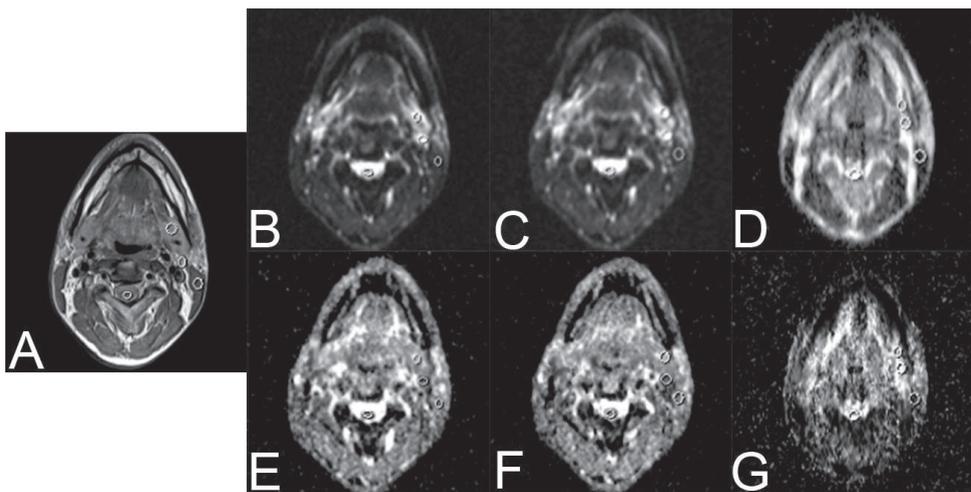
Example of regions of interest (ROIs) drawn on T2 (A), EPI-DWI-2b b_0 (B), EPI-DWI-6b b_0 (C), TSE-DWI-2b b_0 (D), EPI-DWI-2b ADC (E), EPI-DWI-6b ADC (F) and TSE-DWI-2b ADC. The tonsils are not visible at this level. Images were acquired with Siemens Avanto.
